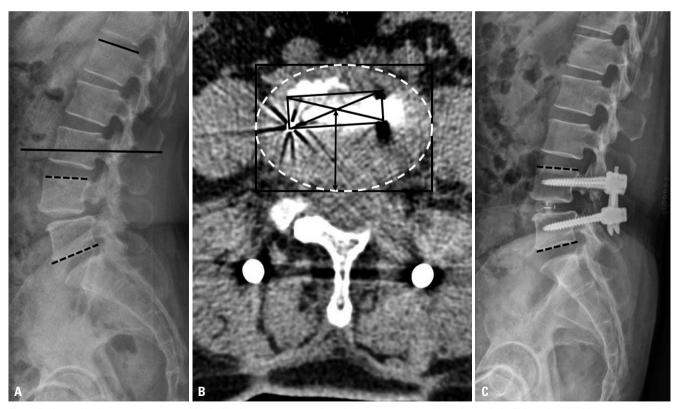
Patient with decreased segmental lordosis after surgery even though the cage was positioned anteriorly. This patient had large preoperative segmental lordosis (black dotted line, 26.6°) and proximal lordosis (black line, 17.7°) (A). Although the cage was positioned anteriorly (black arrow, 67.4%) in the axial CT image (B), postoperative segmental lordosis was decreased by 15.8° (black dotted line) on 1-year postoperative X-ray (C).
